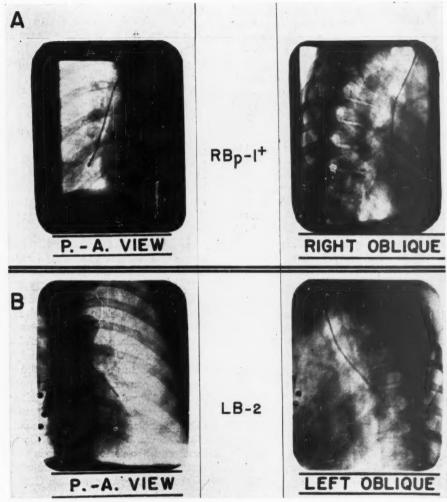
Spot x-ray films demonstrating bronchial electrode in situ on right and left sides. A. RBp-1+ (in posterior branch of right lower bronchus, several inches above the diaphragm): The catheter tip is clearly seen adjacent to the right lateral cardiac border in the posterior-anterior view and to the posterior cardiac border in the right anterior oblique view. B. LB-2 (in left lower bronchus below pulmonary conus region): The catheter tip is located at the middle of the left cardiac border in the posterior-anterior view and adjacent to the posterior cardiac border in the left anterior oblique view.
